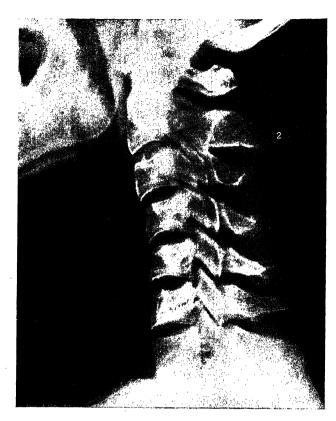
Radiograph of the cervical vertebræ. Lateral view. 1 = anterior arch of atlas; 2 = spine of axis. The curvature is abnormal.
